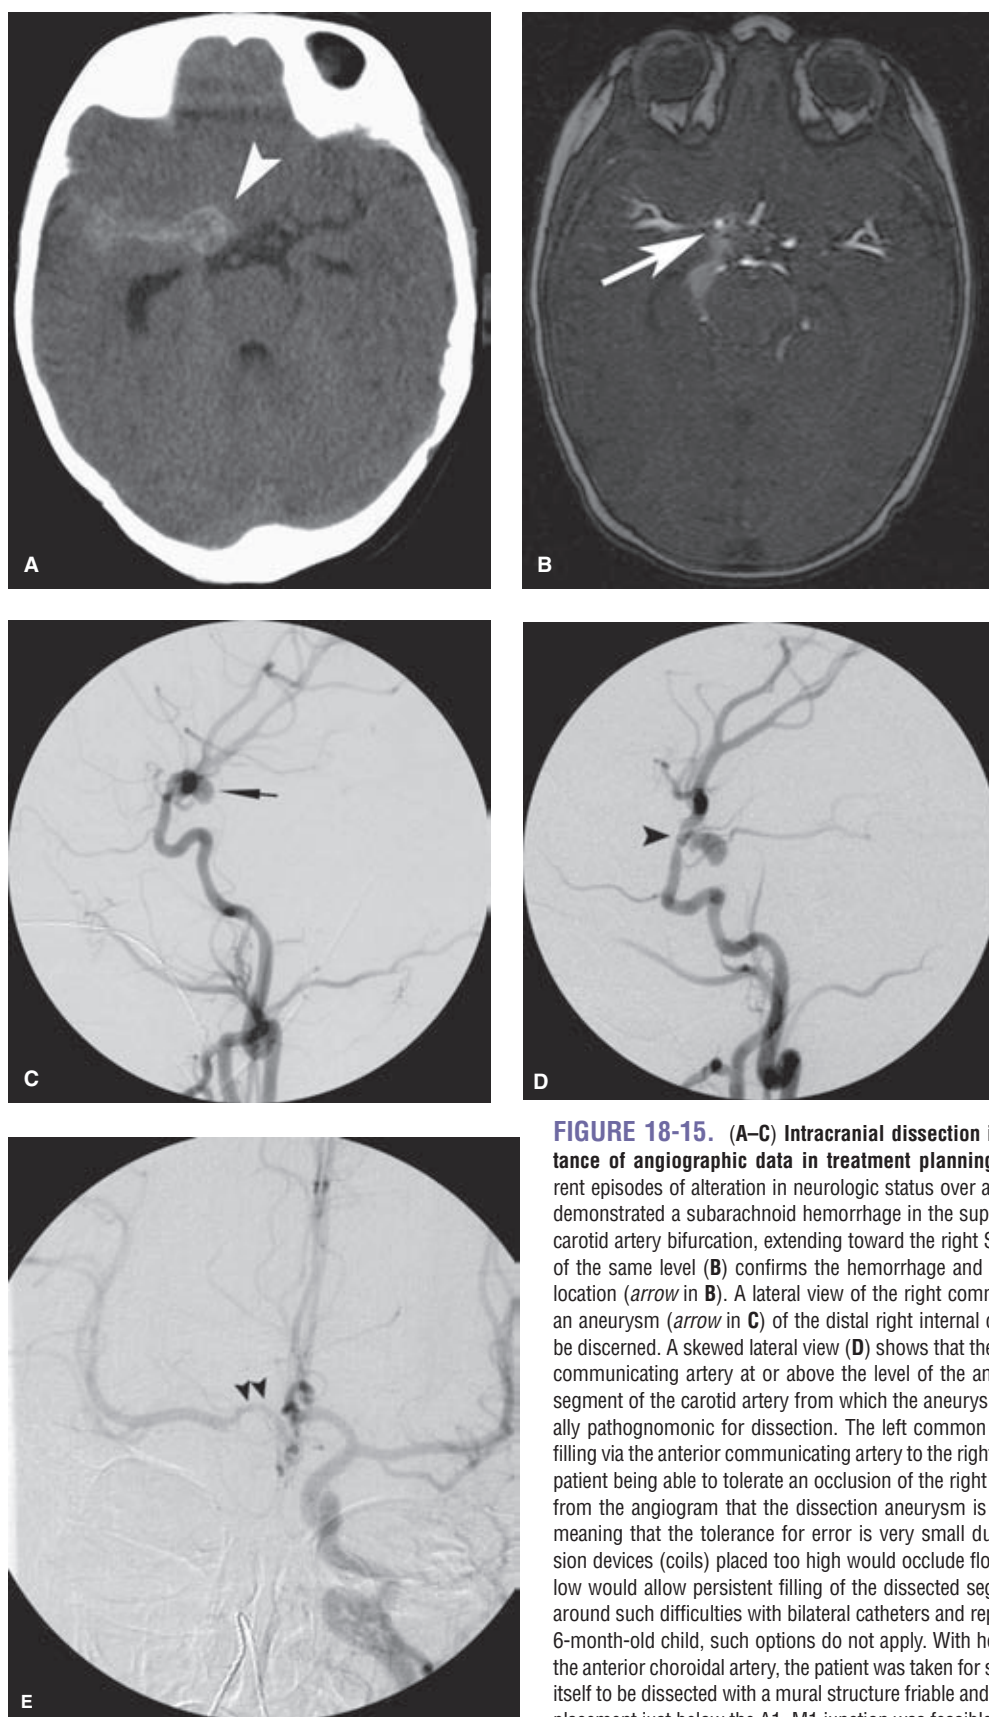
(A–C) Intracranial dissection in a 6-month-old child and the importance of angiographic data in treatment planning. A young infant presented with recurrent episodes of alteration in neurologic status over a 2-week period. Her second CT scan (A) demonstrated a subarachnoid hemorrhage in the suprasellar cistern close to the right internal carotid artery bifurcation, extending toward the right Sylvian region (*arrowhead* in A). An MRA of the same level (B) confirms the hemorrhage and raises suspicion of an aneurysm in that location (*arrow* in B). A lateral view of the right common carotid artery angiogram (C) shows an aneurysm (*arrow* in C) of the distal right internal carotid artery, but its exact origin cannot be discerned. A skewed lateral view (D) shows that the aneurysm is arising above the posterior communicating artery at or above the level of the anterior choroidal artery. Furthermore, the segment of the carotid artery from which the aneurysm arises is narrowed and irregular, virtually pathognomonic for dissection. The left common carotid artery injection (E) shows cross filling via the anterior communicating artery to the right A1 (*arrowheads* in E), auspicious for the patient being able to tolerate an occlusion of the right internal carotid artery. It can be deduced from the angiogram that the dissection aneurysm is very close to the right A1–M1 junction, meaning that the tolerance for error is very small during an endovascular procedure. Occlusion devices (coils) placed too high would occlude flow to the middle cerebral artery while too low would allow persistent filling of the dissected segment. In an adult patient, one can work around such difficulties with bilateral catheters and repeated test injections of contrast, but in a 6-month-old child, such options do not apply. With hopes of preserving the carotid artery and the anterior choroidal artery, the patient was taken for surgical exploration, but the artery proved itself to be dissected with a mural structure friable and tattered beyond repair. Fortunately, a clip placement just below the A1–M1 junction was feasible with a successful outcome.
